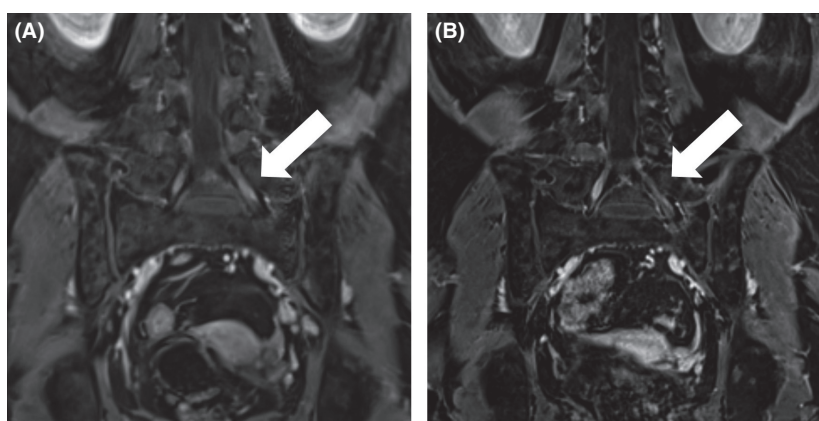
Coronal images from gadolinium-enhanced magnetic resonance imaging at initial diagnosis of neurolymphomatosis (Panel A), and after treatment with bendamustine (Panel B). Enlargement and strong postgadolinium enhancement of the left sacral nerve that was observed at diagnosis (Panel A, arrow) disappeared after six courses of treatment with bendamustine and rituximab (Panel B, arrow).
